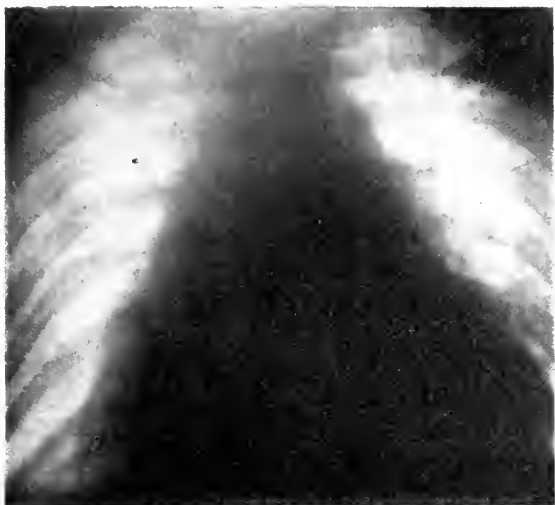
Nels W. Roentgenogram taken April 24, 1916.
